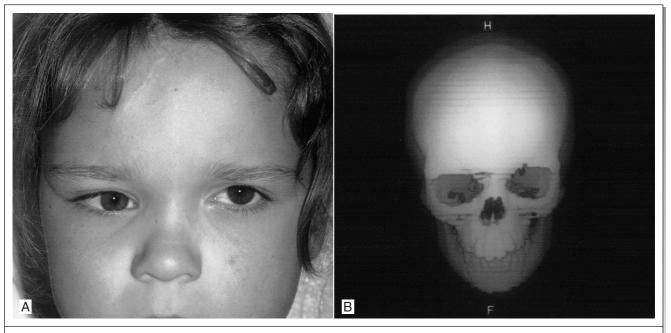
• A, Delayed manifestation of an untreated orbital roof fracture. Notice the true orbital dystopia. B, Three-dimensional computed tomography of the same patient demonstrating the flattened, remodeled orbital roof and bony orbital dystopia.
